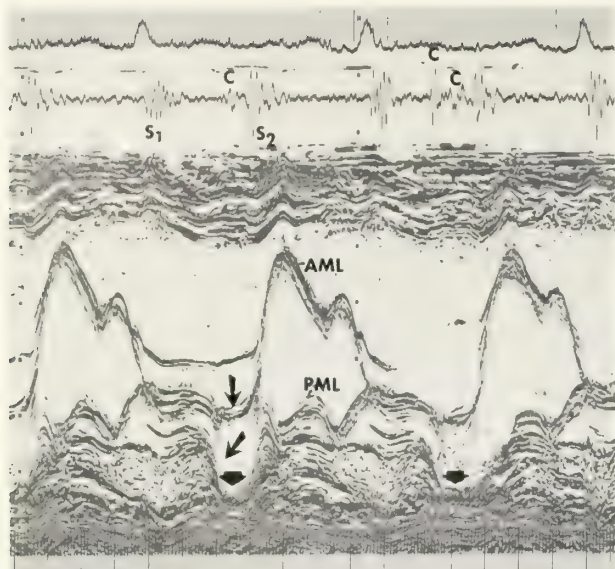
Echocardiogram from patient with mitral valve prolapse. Note end-systolic posterior motion (arrows). Arrowheads denote ancillary finding representing the left atrial posterior wall moving posteriorly at end-systole synchronous with the valvular prolapse.
